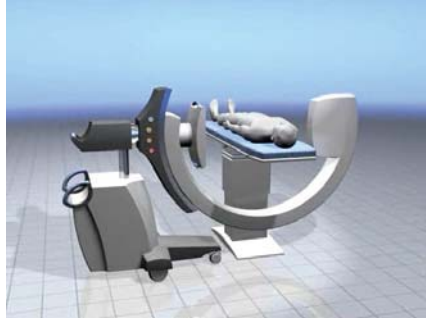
Geometry of CBCT projection with a planar detector
